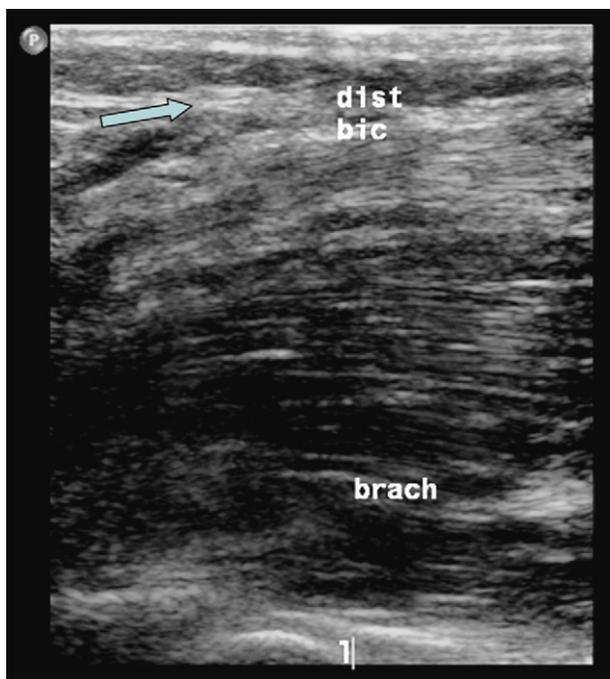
An ultrasound image of the elbow shows the normal biceps tendon (*arrow*) and the brachialis underneath.
